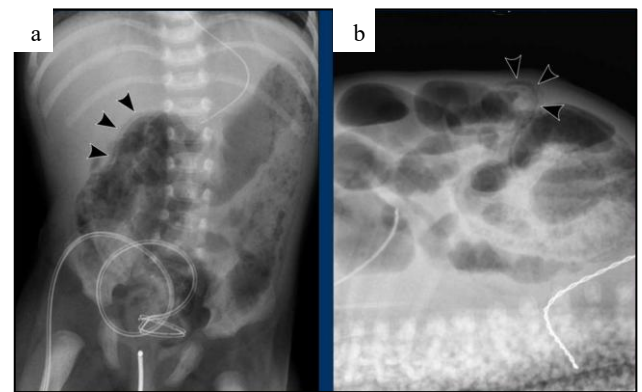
(a and b): AP and lateral views of abdominal X-ray demonstrating dilated loops of bowel and pneumatosis intestinalis, typical features of NEC.
